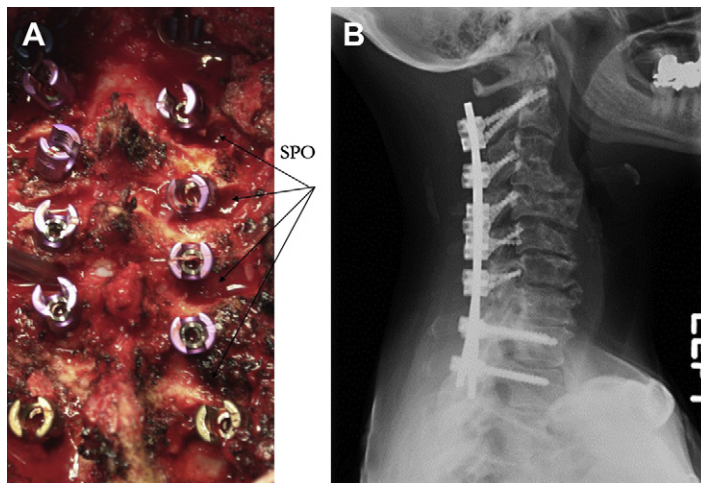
Case example of semirigid deformity treated with SPO. (A) Intraoperative photograph showing the cervical kyphotic correction using multiple SPOs. (B) Postoperative lateral radiograph showing correction of the cervical kyphosis and use of a cobalt chromium rod.
